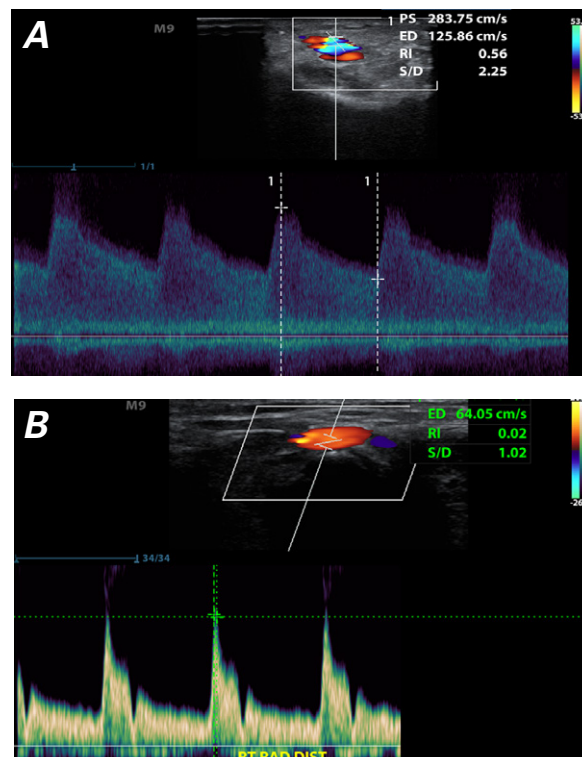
Duplex ultrasonograms of the right distal radial artery show A) an arteriovenous fistula at the anatomic snuffbox access site and B) its resolution after 4 hours of compression therapy.
